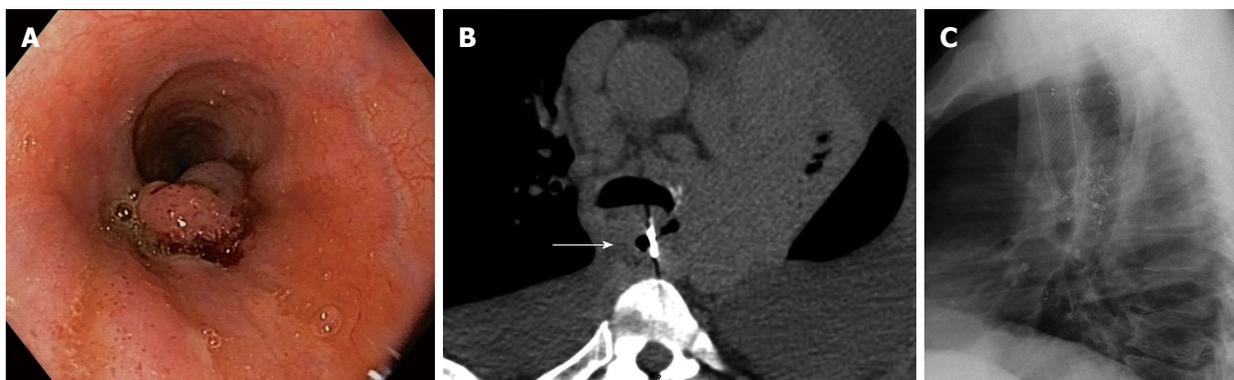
Endoscopic view after the Padlock Clip™ displacement (A). Computed tomography control (B) showing the clip (white arrow) positioned at the esophageal edge of the fistula. Rx control (C) after the esophageal self-expandable metal stent release.
